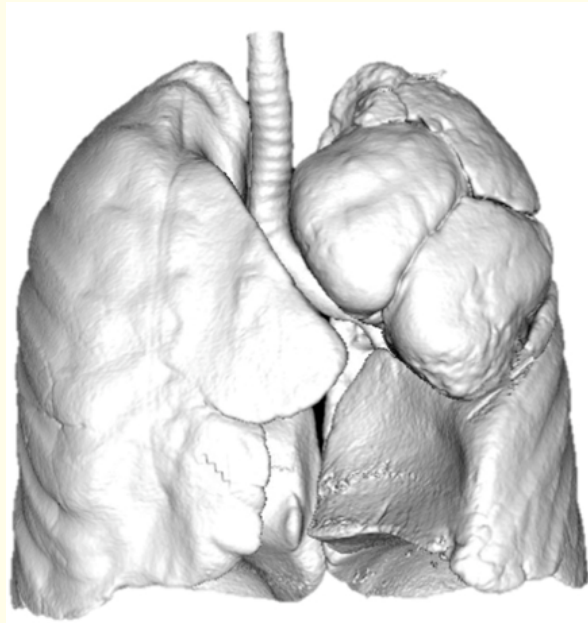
Chest x-ray and tomography with cystic adenomatoid malformation in the left upper lobe.
